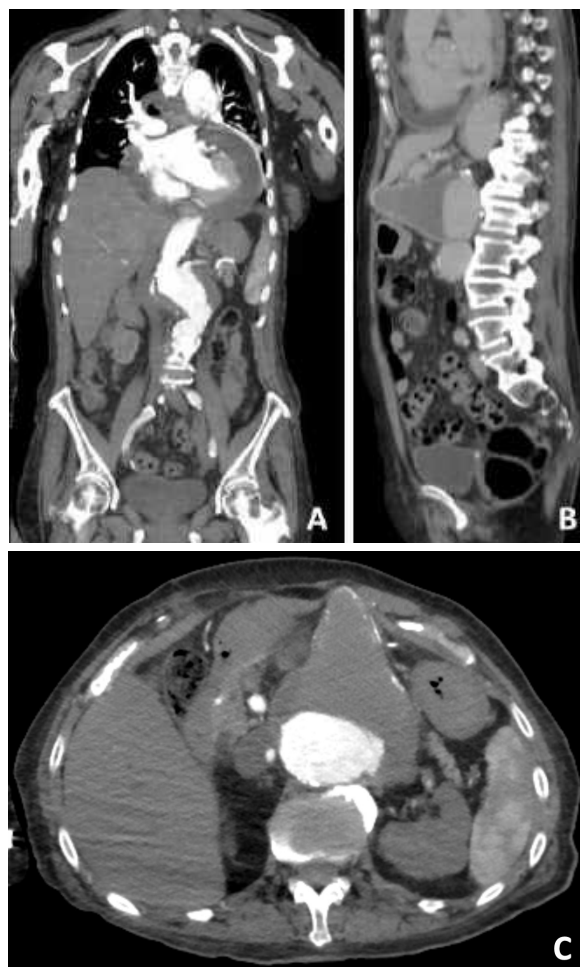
Computed angiogram (CTA) showing a large abdominal aortic aneurysm with a conical shape and contained rupture (A - coronal, B - sagittal and C - axial planes).
